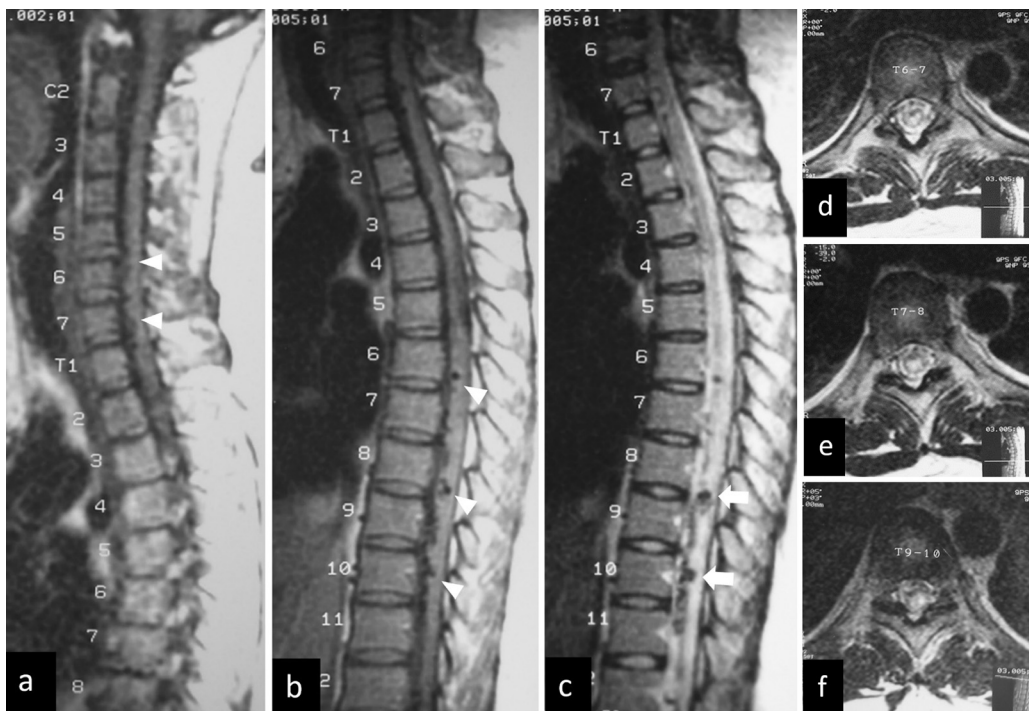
Sagittal T1-weighted images of (A) the cervical and (B) thoracic spine show intradural flow voids (*arrowheads*) along the anterior surface of the spinal cord extending from the lower thoracic to lower cervical level. (C) Sagittal T2-weighted image of the thoracic spine demonstrate two venous varices (*arrows*) at the level of T8–9 and T10. Axial T2-weighted images at the level of (D) T6–7, (E) T7–8, and (F) T9–10 reveal abnormal hypersignal intensity within the spinal cord, representing spinal venous congestion.
